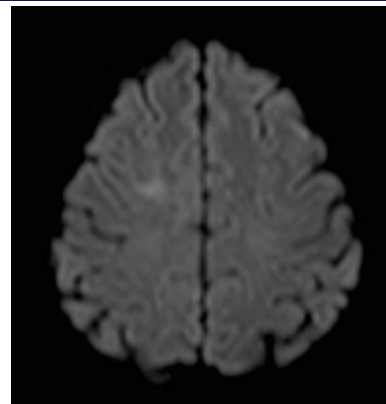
Diffusion Weighted Image [DWI] Brain: Subtle Hyperintense Area Seen in Right High Frontal Region With Adjacent Mild Cortical Thickening and Swelling.
